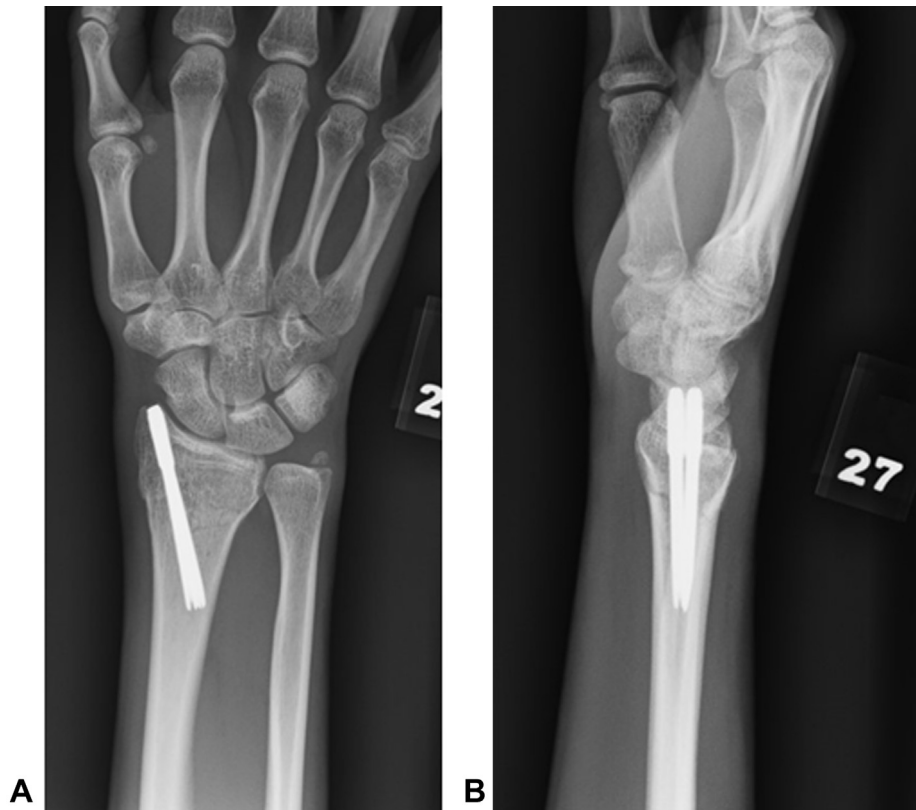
A, B Postoperative radiographs of a distal radius fracture with threaded pin fixation.
